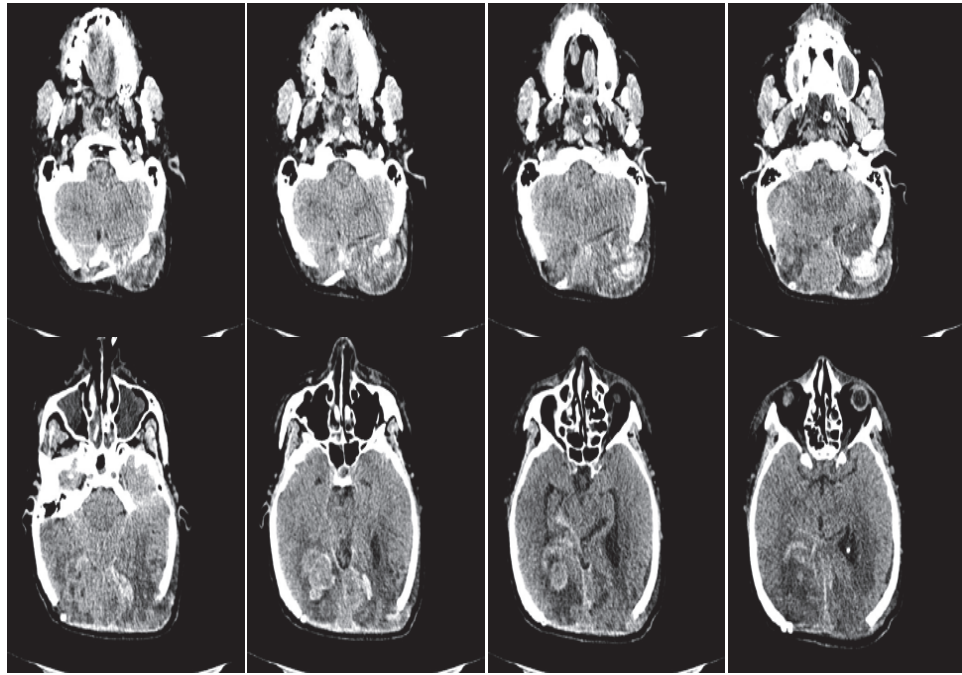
CT scan images of patient with occipital bone fracture
